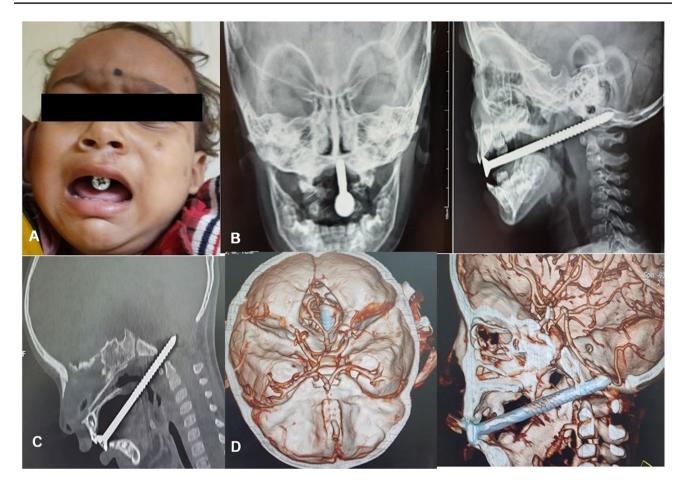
A- Clinical image of shank screw stuck in the oral cavity. B-X-ray skull AP and lateral view showing the skull entering the posterior fossa. C- Mid sagittal computer tomography image showing
